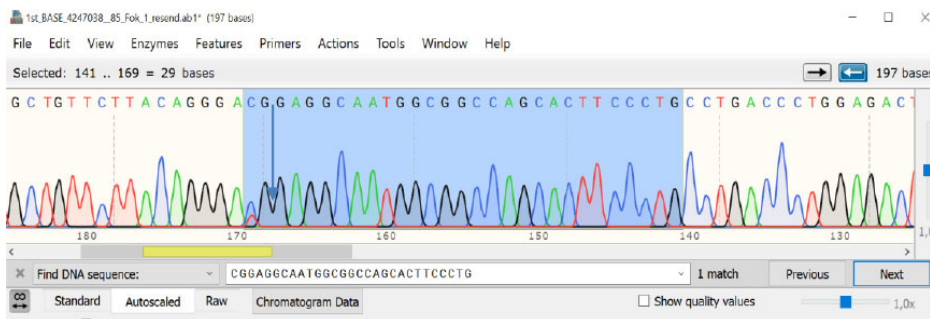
Visualization Of Sanger Sequencing Results from CT. Heterozygous Genotype PCR Products.
